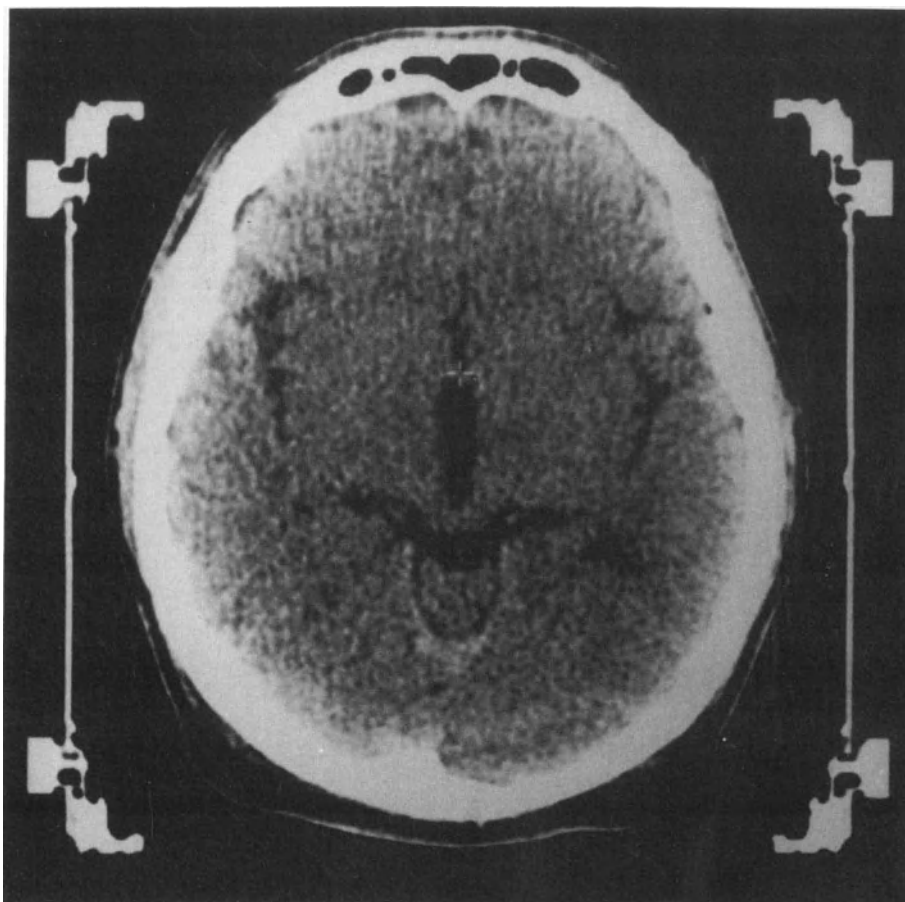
Identification of the posterior commissure (A) and anterior commissure (B) by CT using the CT-compatible Leksell frame. The locations of the commissures and of the six fiducial bars on either side of the frame allow the X, Y, and Z coordinates to be read directly from the CT images.
